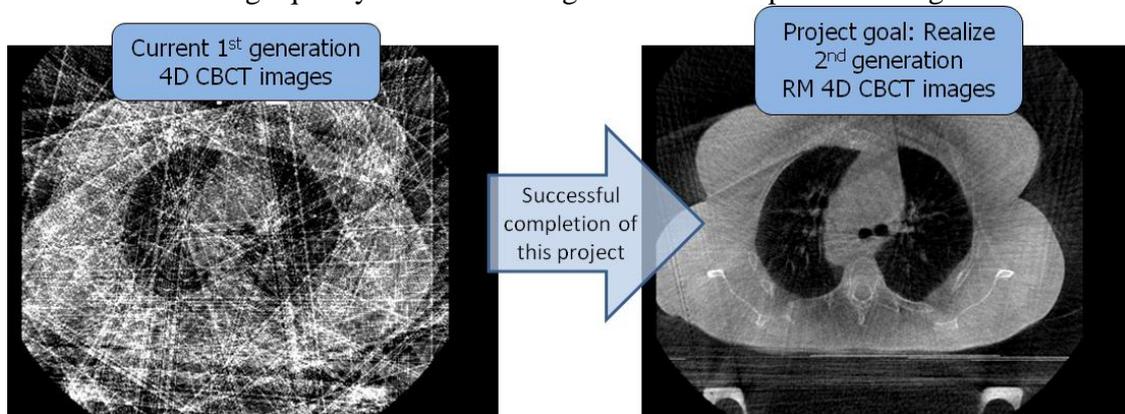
Our research goal is to transform current 1st generation artefact-filled 4D CBCT images (left) into substantially improved clinically useful images (preliminary data right) by developing and investigating RM 4D CBCT. Note the same amount of data (240 projections) was used to create both images. The images have the same windowing settings.
